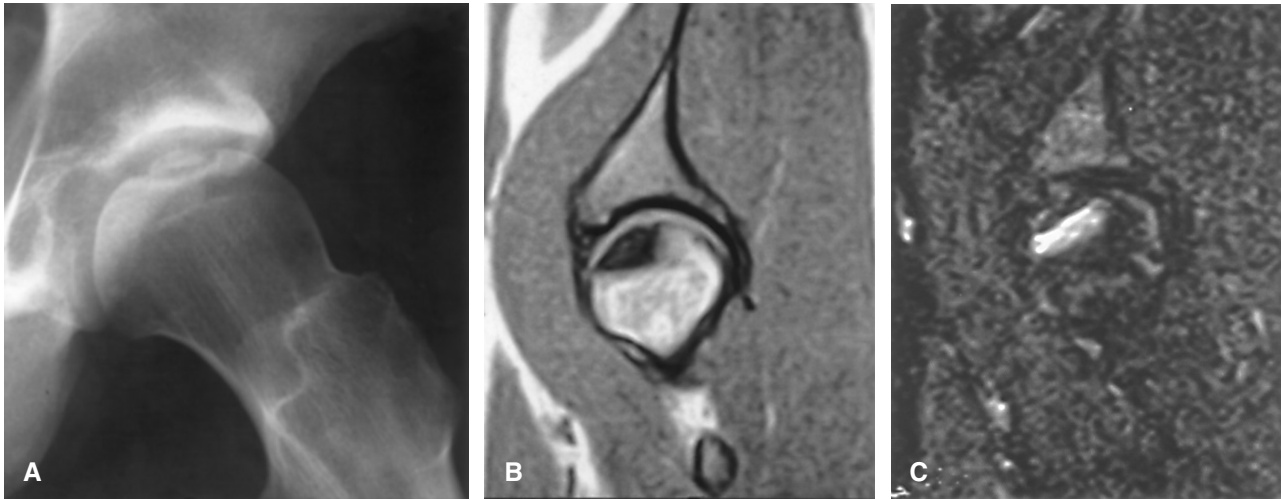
Patient 1. A) Lauenstein view of the left hip at age 18. B) and C). MR at age 22. T1-weighted sagittal view in (B) shows low signal intensity, while the STIR sequence (C) shows marked edema in and around the lesion.
